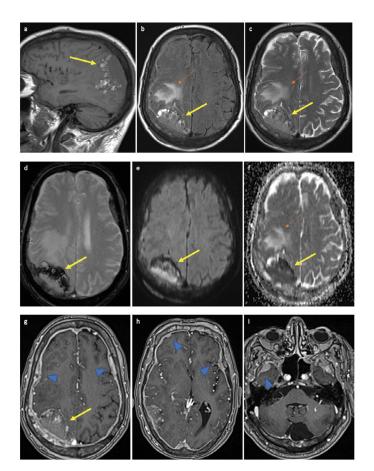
Cerebral MRI with T1-weighted sagittal (a), axial FLAIR (b), T2 SE (c), T2 EG (d), diffusion (e) with ADC cartography (f), and 3D T1 (g-i). EG images showing right extra-axial process with bony attachment (yellow arrow) and a heterogeneous signal containing hemorrhagic zones in hyper signal T1 and T2. This process compresses the cerebral parenchyma and is responsible for vasogenic edema (orange arrow). It is also associated with a diffuse contrast-enhanced and nodular meningeal thickening (arrowheads).
